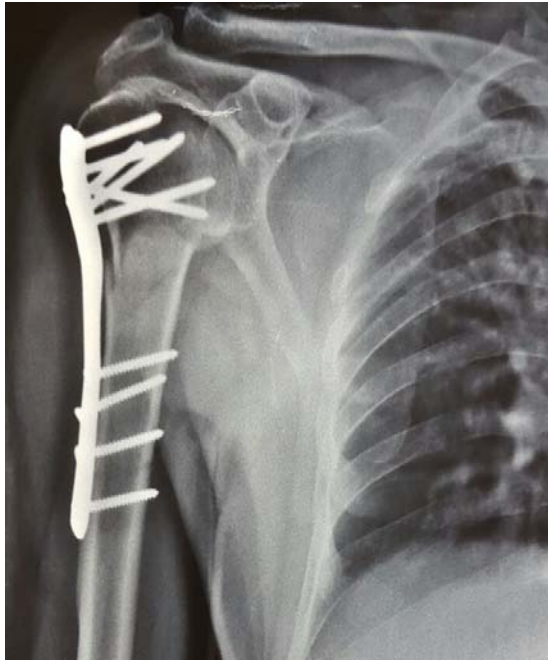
Post-op X-ray: PHILOS plating- Inadequate reduction
